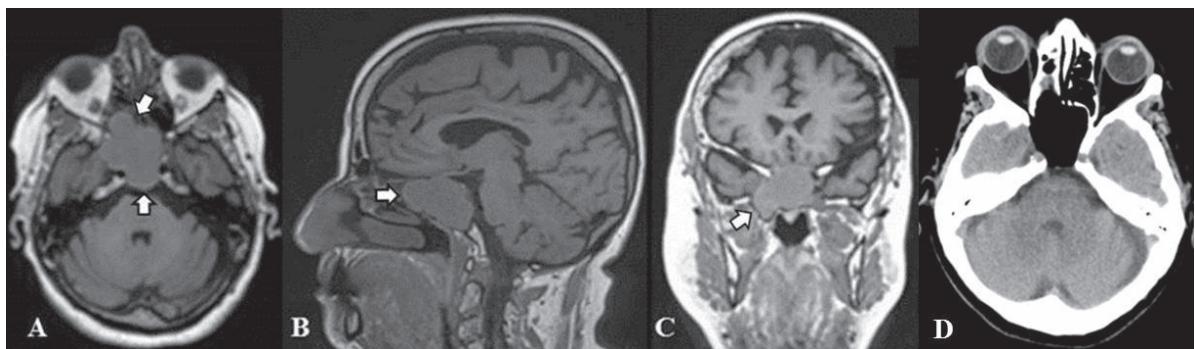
Female patient suffering from mucocele affecting the sphenoid sinus and posterior ethmoidal cells who presented with proptosis and right oculomotor nerve palsy. T1 MRI images in axial, sagittal and coronal planes (A-C) – isointense lesion eroding the bone of the sphenoid sinus and posterior ethmoidal cells that propagates to the intracranial space and compresses the right cavernous sinus; (D) Postop CT demonstrating efficient drainage of the mucocele following endoscopic marsupialization.
